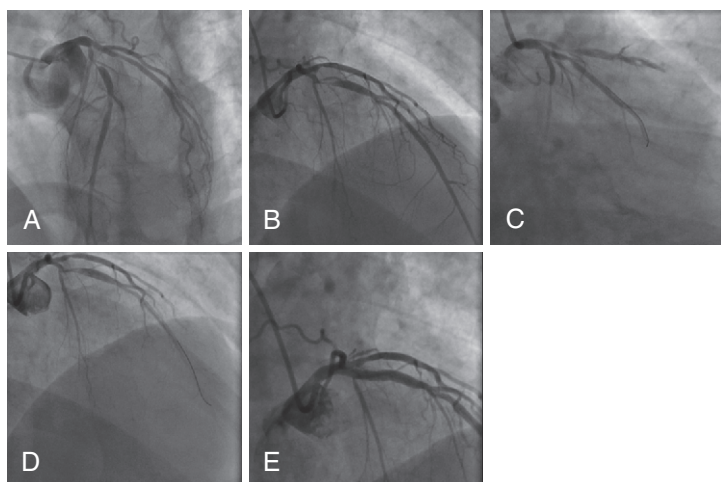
Cine frames from multivessel PCI guided by FFR. A, LAO cranial view of LCA showing severe and moderate lesions in LAD and CFX. B, RAO view of LCA. C, FFR of CFX was 0.88. D, PCI of LAD performed. E, Mid LAD lesion assessed by FFR at 0.68. An additional stent was placed, and IVUS was performed. Final result of fully deployed stents with FFR 0.89. CFX, circumflex artery; FFR, fractional flow reserve; IVUS, intravascular ultrasound; LAD, left anterior descending; LAO, left anterior oblique; LCA, left coronary artery; PCI, percutaneous coronary intervention; RAO, right anterior oblique; RCA, right coronary artery.
